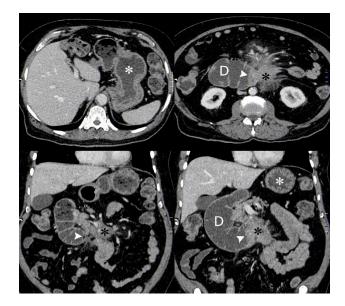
Follow up axial (top row) and coronal (bottom row) venous phase contrast enhanced CT images performed 11 months after initial diagnostic CT when patient represented with symptoms of reduced appetite and abdominal swelling. The degree of gastric dilatation (white asterisk) is considerably less than on the initial CT. The mesenteric mass (black asterisk) has significantly reduced in volume following chemotherapy but the duodenum (D) is more dilated and obstructed at the 3rd part (white arrowhead), possibly due to post treatment fibrosis.
